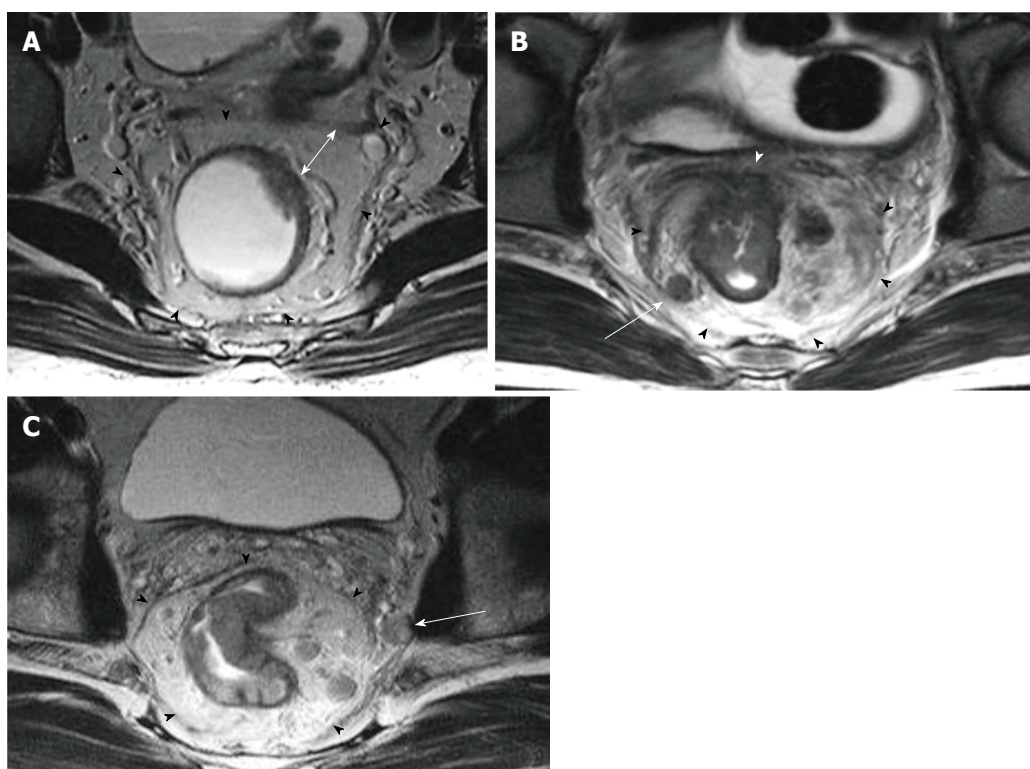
Distance to mesorectal fascia and mesorectal fascia invasion in different patients on T2-weighted axial images. A: T3a tumor is far away from the mesorectal fascia (double-headed arrow); B: T4a tumor (white arrowhead) and a suspicious mesorectal lymph node (arrow) are abutting the mesorectal fascia; C: Rectal tumor is lying > 1 mm from the mesorectal fascia; however, a suspicious lymph node, located out of the mesorectal fascia, is lying within < 1 mm of the mesorectal fascia (arrow). Mesorectal fascia is indicated with black arrowheads.
